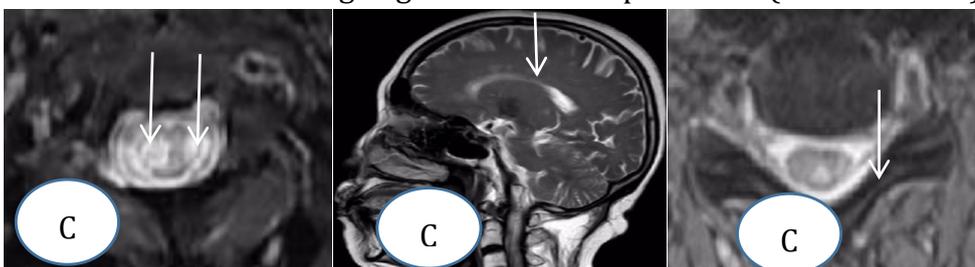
Figure C(the early-onset patient): C1, STIR highsignal in the cross section of the cervical spinal cord (December 2021) . C2, Dotted FLAIR highsignal in the sagittal plane of the head (December 2021). C3, STIR highsignal in the cross section of the cervical spinal cord (October 2021).
